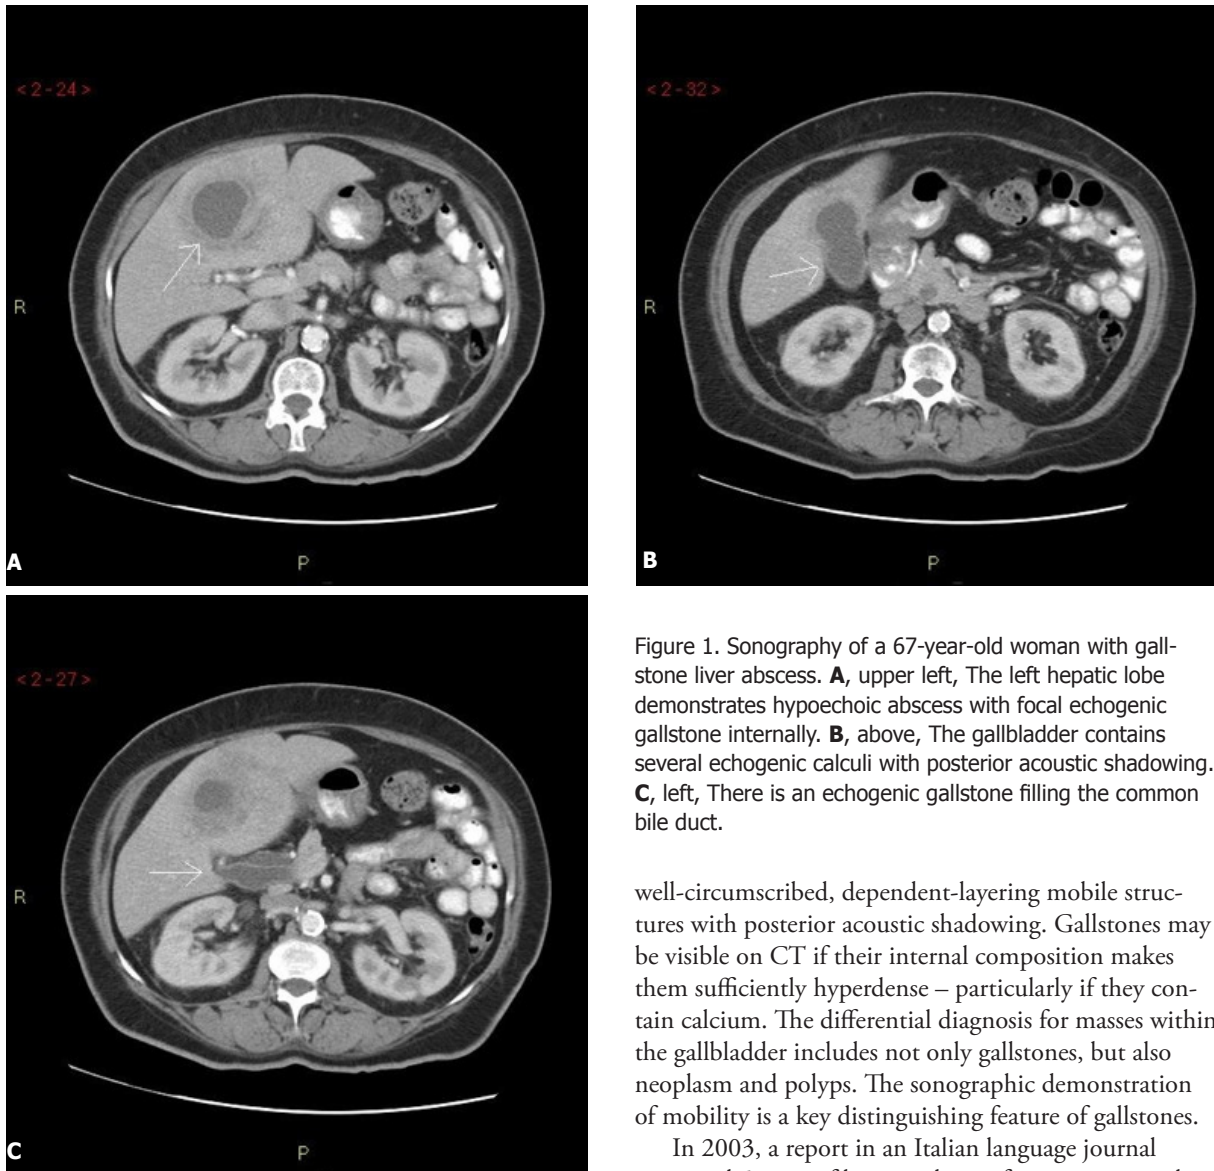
Sonography of a 67-year-old woman with gallstone liver abscess. A, upper left, The left hepatic lobe demonstrates hypoechoic abscess with focal echogenic gallstone internally. B, above, The gallbladder contains several echogenic calculi with posterior acoustic shadowing. C, left, There is an echogenic gallstone filling the common bile duct.
